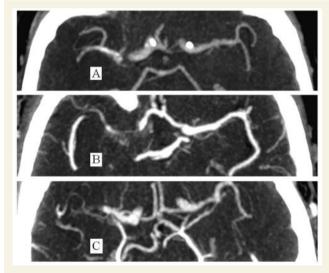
CT angiograms showing axial views of three right MCA occlusions with (A) good, (B) moderate and (C) poor reconstitution of the distal MCA.
